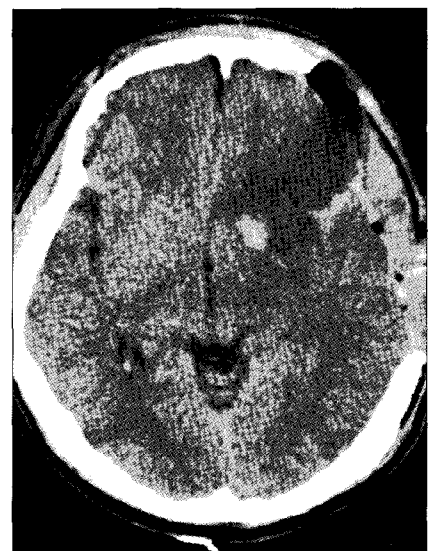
Postoperative brain computed tomographic scans after second operation shows more extensive and definitive low density area in frontal lobe.
